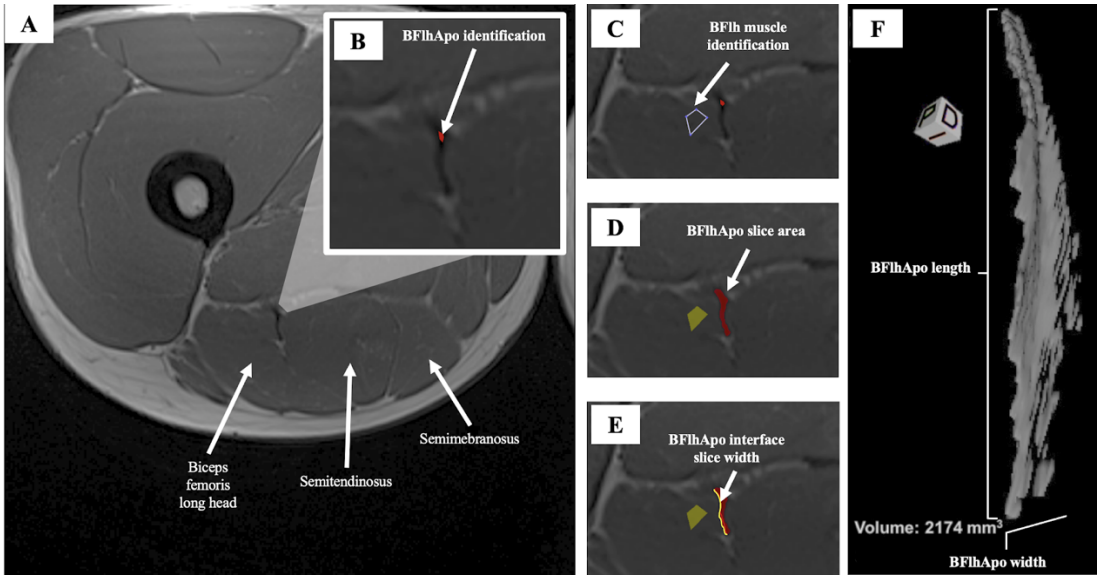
Matlab routine procedure overview from A to E; A. Uploaded MRI slice in .dicom format and anatomical identification of the hamstrings; B. Zoom to define the BFLhApo region of interest; C. Zoom to define the BFLh muscle region of interest; D. Automatic calculated slice area with the anatomical threshold criteria at 60% manually set; E. BFLhApo interface slice width, set by a curvilinear line between the BFLhApo and the BFLh muscle belly (yellow); F. Osirix three dimensional view image of the BFLhApo with volumetric value (P - posterior side; D - right side; I - inferior side)
